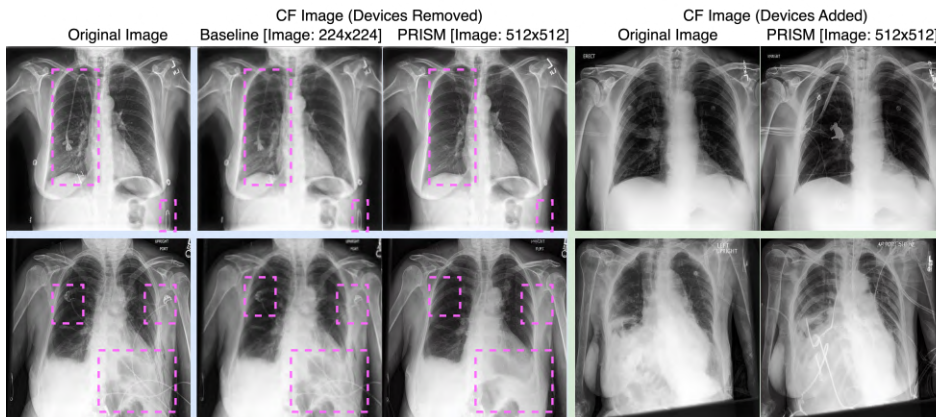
Sample pairs of original and CF images demonstrate the capability of PRISM to remove and add medical devices (e.g. wires, pacemaker) in high resolution. Left: CF images with medical devices removed. Language guidance is T : chest xray of the patient with lots of medical devices, T' : chest xray of the patient without medical devices. Note that the baseline method cannot properly remove medical devices; Right: CF images with added medical devices. Language guidance is T : chest xray of the patient with no support devices, T' : chest xray of the patient with lots of support devices.
